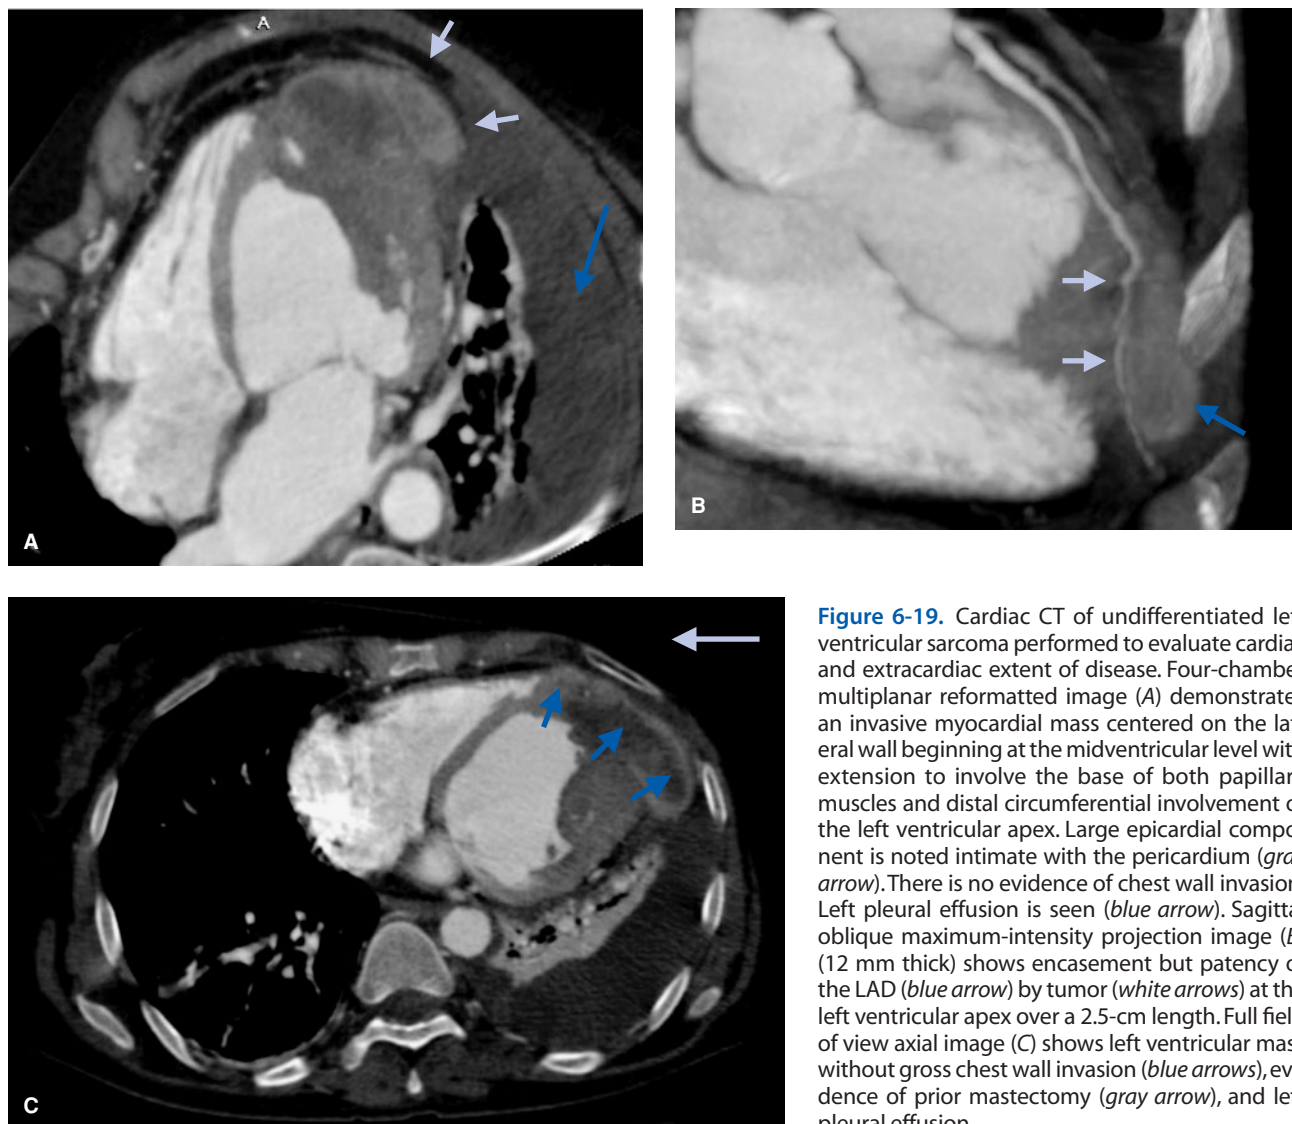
Cardiac CT of undifferentiated left ventricular sarcoma performed to evaluate cardiac and extracardiac extent of disease. Four-chamber multiplanar reformatted image (A) demonstrates an invasive myocardial mass centered on the lateral wall beginning at the midventricular level with extension to involve the base of both papillary muscles and distal circumferential involvement of the left ventricular apex. Large epicardial component is noted intimate with the pericardium (gray arrow). There is no evidence of chest wall invasion. Left pleural effusion is seen (blue arrow). Sagittal oblique maximum-intensity projection image (B) (12 mm thick) shows encasement but patency of the LAD (blue arrow) by tumor (white arrows) at the left ventricular apex over a 2.5-cm length. Full field of view axial image (C) shows left ventricular mass without gross chest wall invasion (blue arrows), evidence of prior mastectomy (gray arrow), and left pleural effusion.
